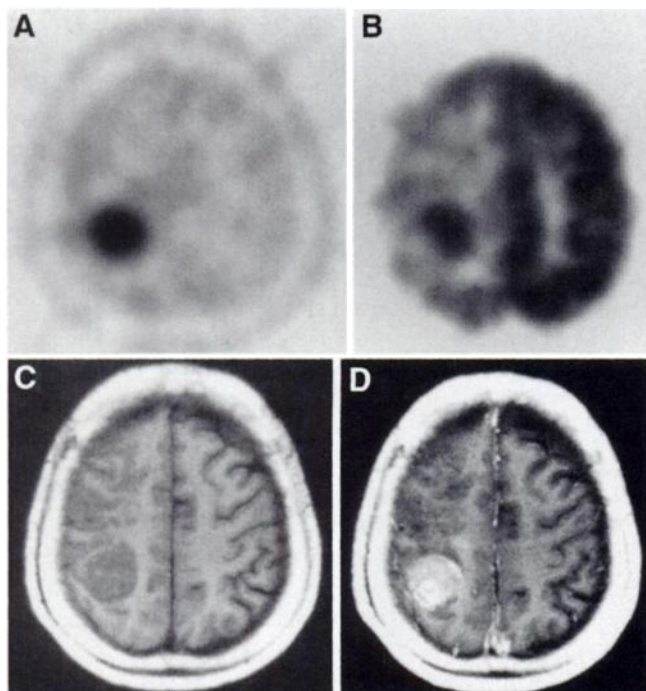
60-y-old woman with astrocytic tumor grade III (patient 10). (A) FMT PET image obtained at 30 min postinjection shows intense tumor uptake of SUV 8.2. (B) FDG PET image obtained at 50 min postinjection also demonstrates hypermetabolic tumor of SUV 9.9 associated with inhibition of glucose metabolism surrounding lesion. Markedly enhanced lesion was recognized on T1-weighted MR images obtained without (C) and with (D) contrast media.
